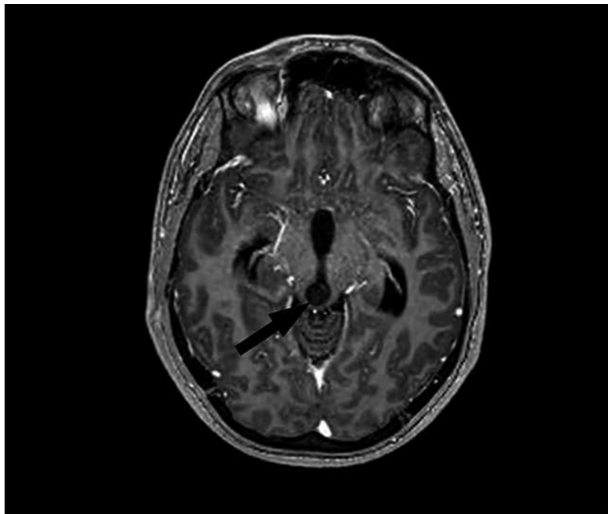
Axial T1 MRI scan of patient #1; the arrow's tip indicates where the tectal lesion is. Please note the enlarged ventricles' size.
